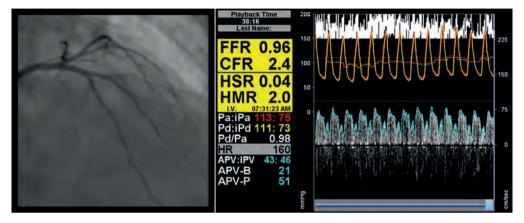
Coronary angiogram showing the visual result after PCI was performed of the intermediate stenosis in the first diagonal branch. In addition, combined pressure and Doppler flow velocity recordings were repeated using a ComboWire* (Volcano Corp.). A stable Doppler flow signal was established by flipping the tip of the ComboWire (Figure 1), and obtaining the Doppler signal retrogradely.
